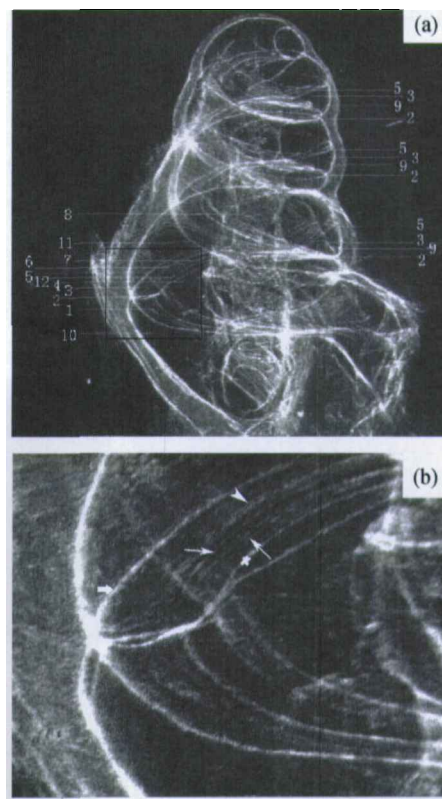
DEI peak image recorded by X-ray film and its magnified image of the selected region. The energy of X-ray was 8 keV and stream intensity was 60 mA. (a) 1, basilar membrane; 2, basilar membranous crest; 3, cochlear duct; 4, spiral lamina; 5, vestibular membrane; 6, limbus of Hansen cell; 7, static cilia of hairy cell; 8, modiolus; 9, spiral prominence; 10, tympanic scala; 11, vestibular scala; 12, spiral limbus. (b) Bold arrow refers to basilar membranous crest; thin arrow refers to static cilia of hairy cell; thick arrowhead refers to limbus of Hansen cell; and asterisk refers to spiral limbus.
